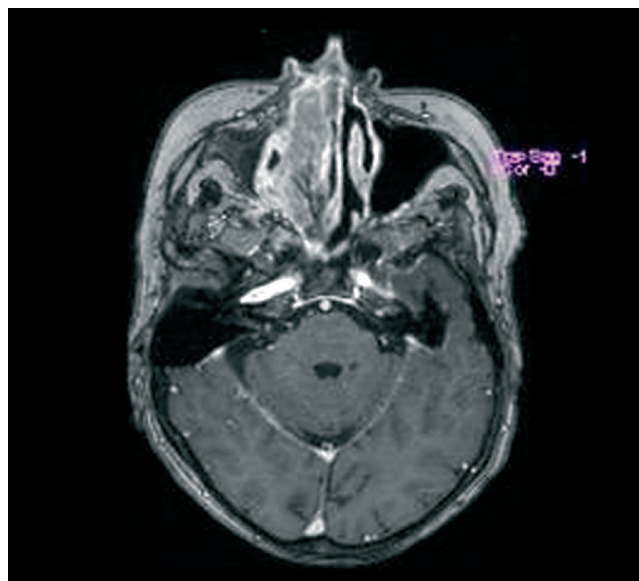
Magnetic resonance images showing a tumor in the right nasal cavity, right maxillary sinus and right ethmoid bone.
